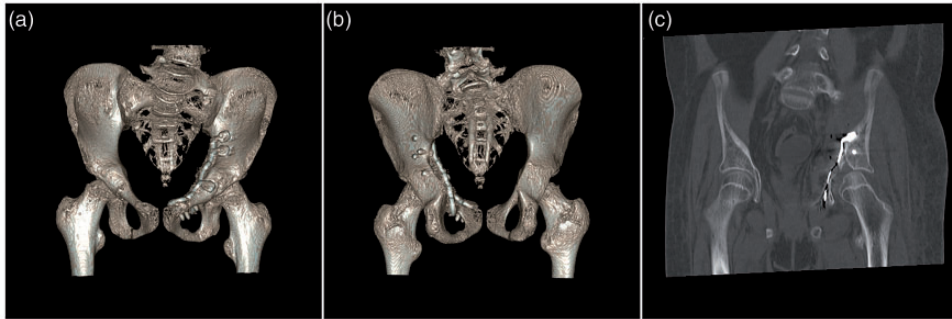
Postoperative computed tomography three-dimensional reconstruction of reduction and fixation. (a) The anterior view of three-dimensional reconstruction showed satisfactory reduction and fixation of the anterior column and wall. (b) The posterior view of three-dimensional reconstruction showed satisfactory reduction and fixation of the posterior column and wall. (c) The coronal plane of computed tomography showed satisfactory reduction and fixation of the quadrilateral plate.
